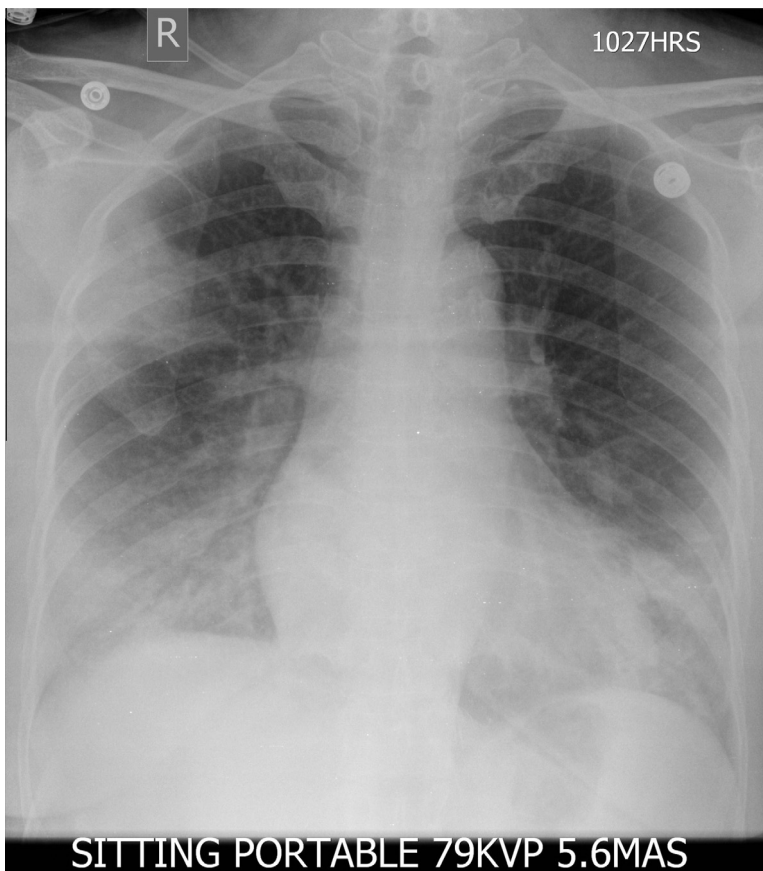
Chest X-ray frontal projection 3 days after presentation showing progression with multifocal peripheral pulmonary opacities.
